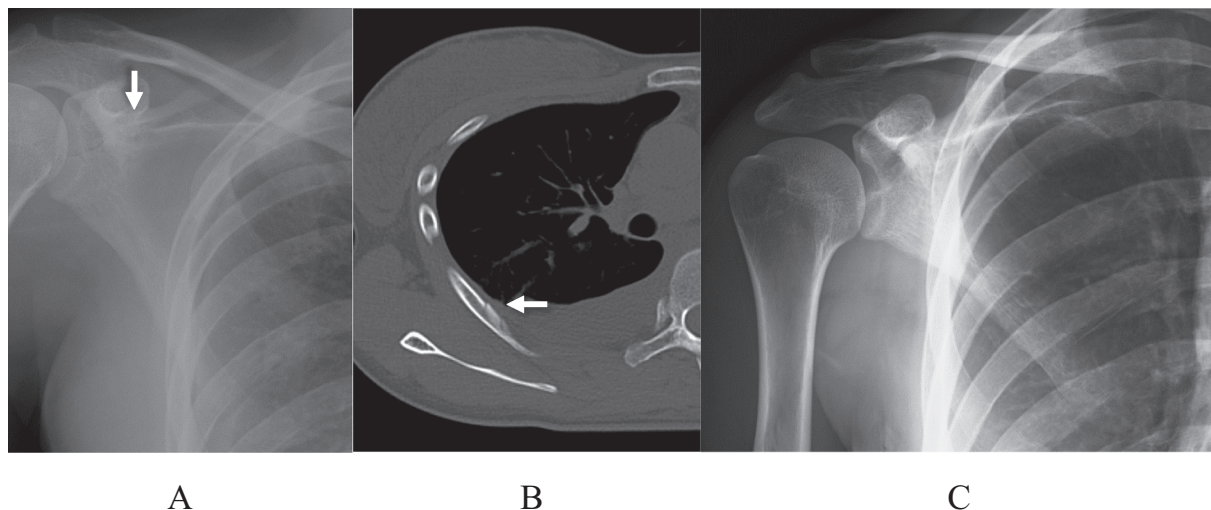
A 24-year-old female. A) Anteroposterior radiograph demonstrating right Ideberg type III glenoid fracture. B) Axial CT demonstrating right sixth rib fracture. The right fifth through ninth ribs were fractured. C) Anteroposterior radiograph 1 year after the injury demonstrating bone union of the fracture and no degenerative changes in the right shoulder joint.
